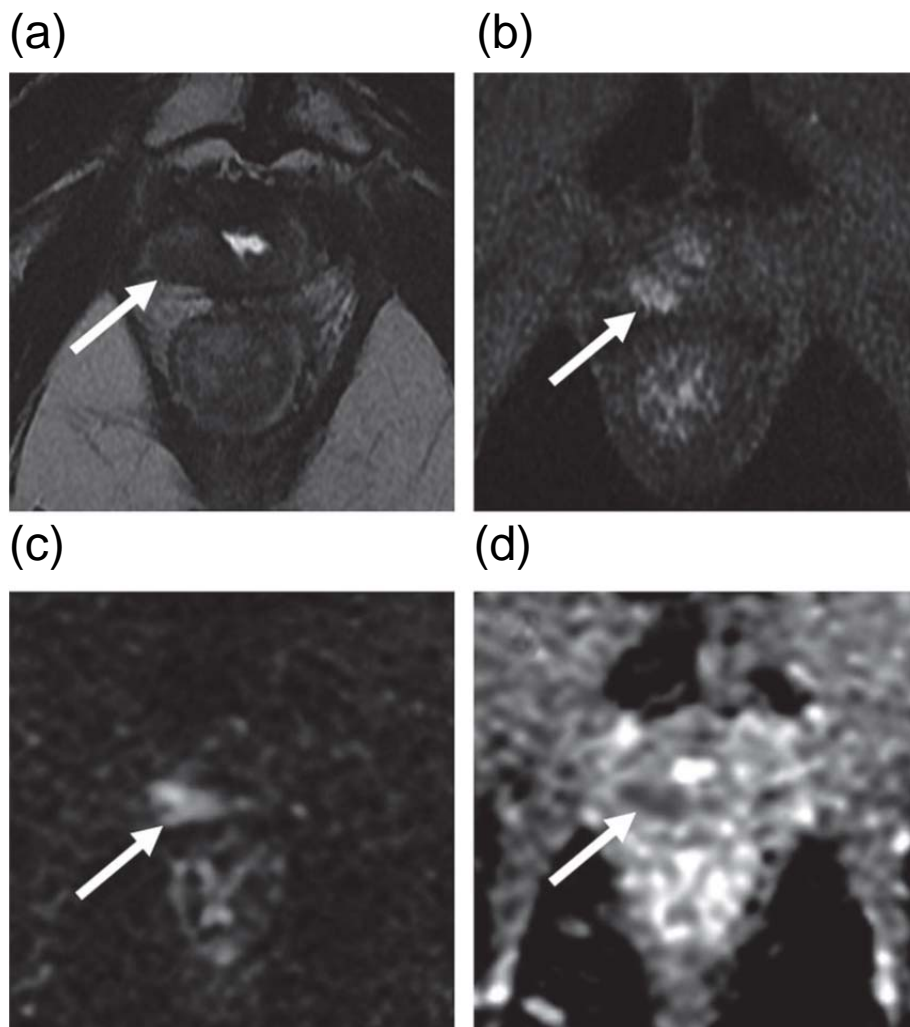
A 83-year-old patient with recent elevation of prostate-specific antigen level to 2.3 ng/mL at 9 years after radical prostatectomy. On T2-weighted images (T2WI), a focal area with slightly high intensity is seen within right posterolateral bladder neck (a; arrow). Dynamic contrast-enhanced T1-weighted images show early enhancement corresponding to the finding on T2WI (b; arrow). This lesion shows high signal on diffusion weighted images (c; arrow) and low signal on apparent diffusion coefficient map (d; arrow). These findings suggest localized recurrence of prostate cancer.
